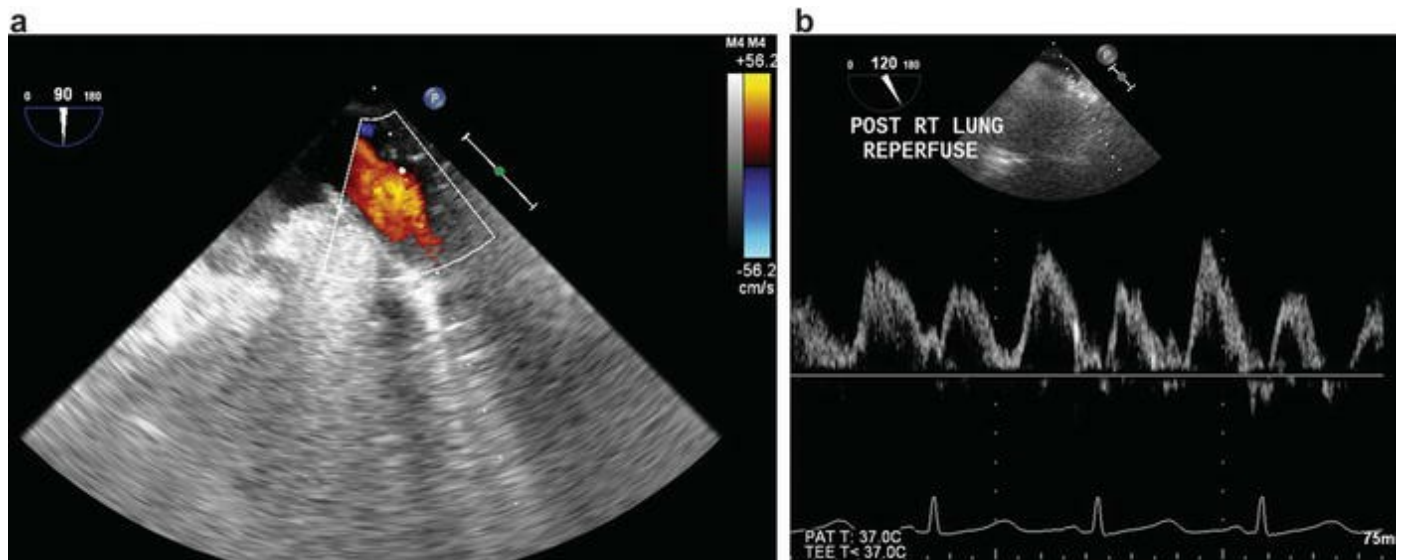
Post lung transplantation evaluation of pulmonary venous anastomosis by color flow (a) and spectral Doppler (b)
